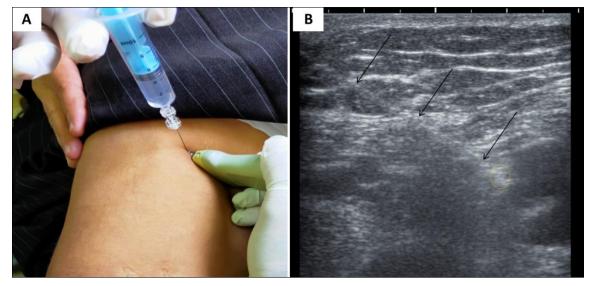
(A) Utilizing ultrasound-guidance, the needle was inserted from the lateral to medial sides of the body to target the saphenous nerve's short axis in a plane approaches. (B) In the adductor canal, the saphenous nerve was indicated by a dotted orange circle and black arrows.
